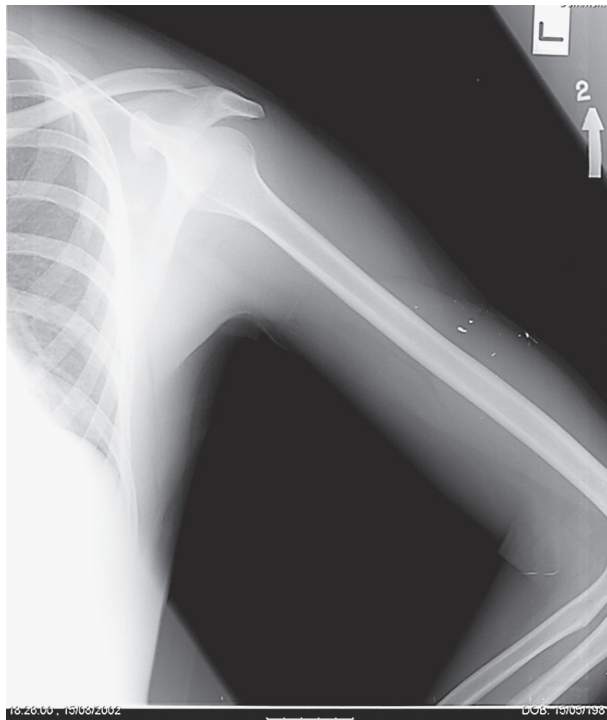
An upper-extremity radiograph shows multiple small subcutaneous metal fragments in a 21-year-old victim of a terrorist attack 5 years prior to the MRI. No adverse sensation was reported during or after the MRI examination of the ankle.
